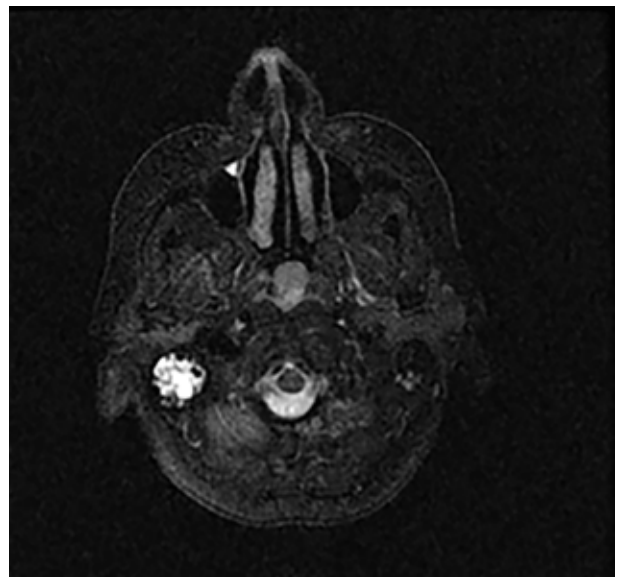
Contrast-enhanced T1 & T2 weighted magnetic resonance imaging (MRI) of nasopharyngeal branchial cyst is seen. The cyst is hyper-intense in T2 weighted images
